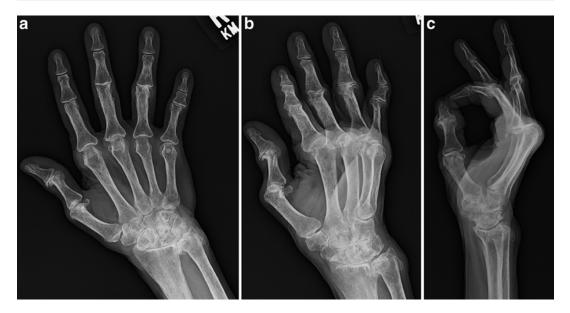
Case #3-Initial X-rays showing subluxation of the index and middle finger MCP joints in the right hand
